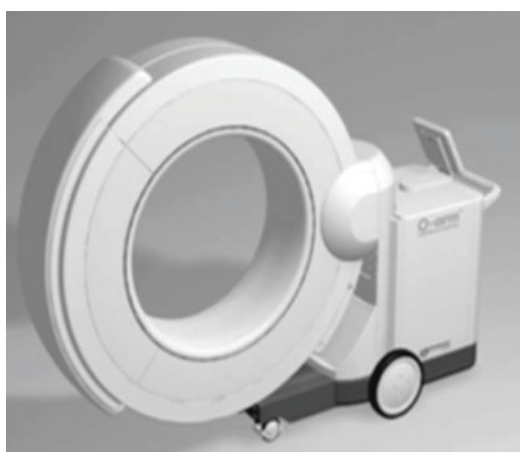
O-arm. Many orthopedic spine surgeons may be more comfortable using C-arm or X-Ray while many neurosurgical surgeons may be more comfortable with modalities like intraoperative CT or “O-arm” imaging. As surgeons continue to “cross-train” in both specialties, these differences are likely to decrease. (Reprinted from Zhang et al. [10], Copyright 2009, with permission from IOS Press. This publication is available at IOS Press through doi: <https://doi.org/10.3233/XST-2009-0231>. <https://content.iospress.com/articles/journal-of-x-ray-science-and-technology/xst00231>)
